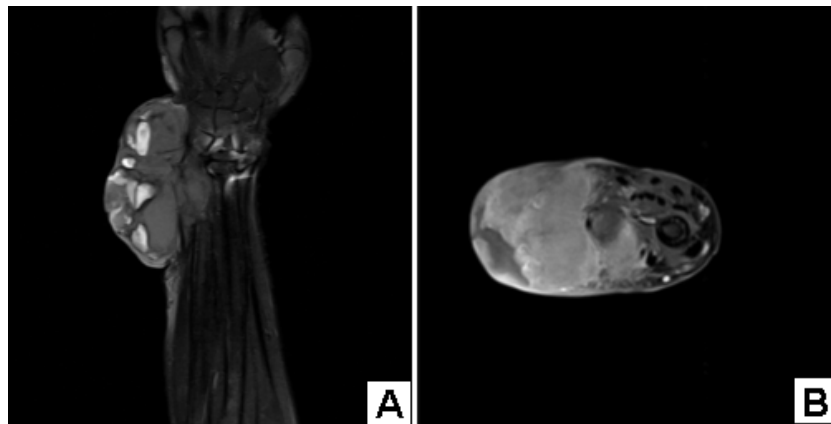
MRI showed multilobulated enhancing solid mass, expanding to the ulnar-side soft tissue. There was small area of cystic component, most probably secondary aneurysmal bone cyst
